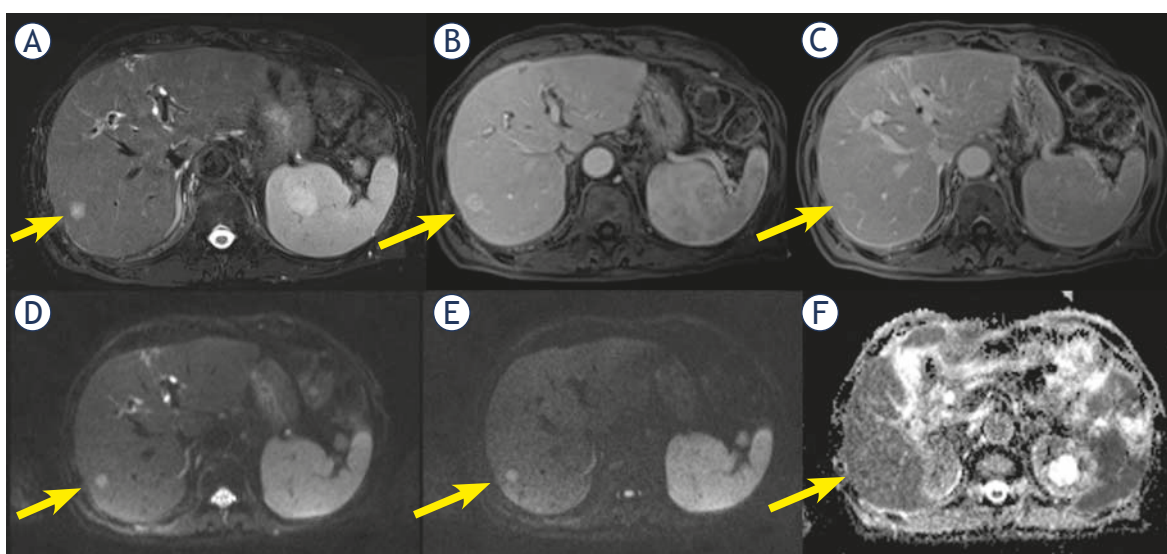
Man 71 y with combined hepatocellular-cholangiocarcinoma (cHCC-CCA) on VI hepatic segment. MRI study. The nodule shows hyperintense signal (arrow) in T2-W sequence (A) and target like pattern of enhancement (arrow) during arterial (B) and portal (C) phase of contrast study. Restricted diffusion (arrow) in diffusion weighted imaging (DWI) (D, E and F) sequence.
